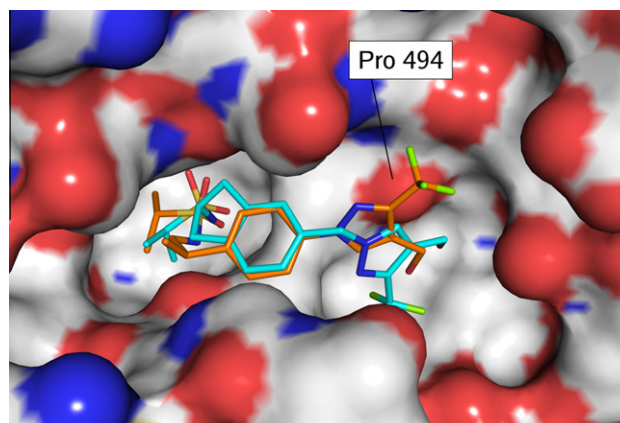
Overlaid X-ray structures of compounds 4 (carbons shown in orange) and 7 (carbons in cyan) in complex with the GluA2 S1S2 LBD. While the central phenyl rings overlay well, the orientations of the pyrazole fragments are very different. For 4, the environment of the trifluoromethyl substituent is different to that observed for a related series [4,5], but the additional methylene in 7 allows the trifluoromethyl to return to the expected position.
